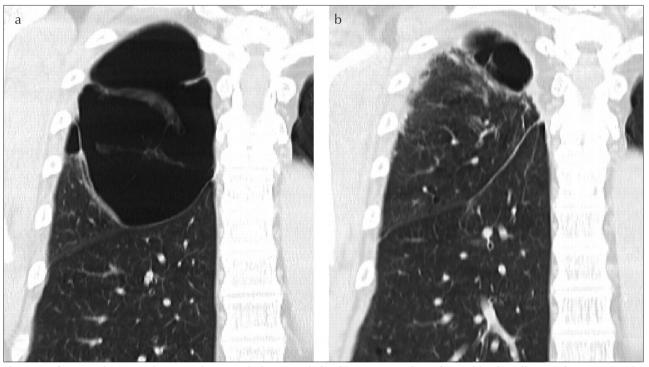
a, b. Coronal computed tomography image, before (a) and after (b) treatment with autologous blood instillation. After treatment, the diameter of the giant bulla decreased from 12 cm to 3 cm *Quoted from ref. 7 with permission
